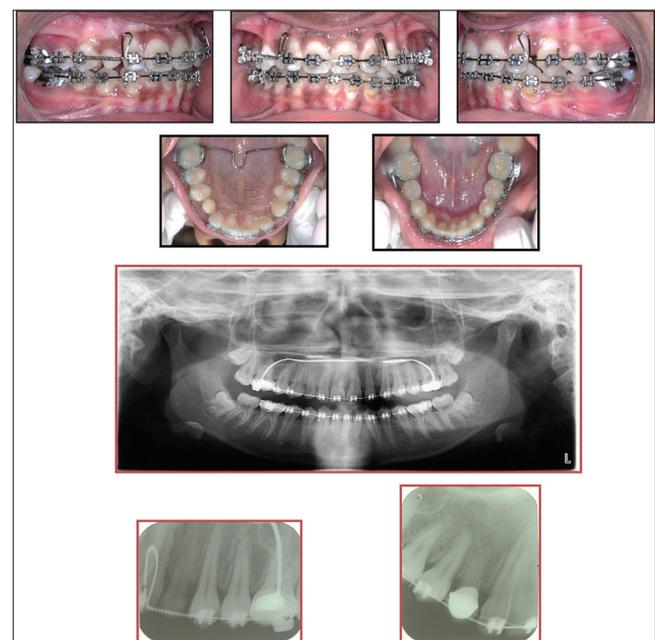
Midtreatment intraoral views and orthopantomogram for the assessment of the root position of 53 following space redistribution toward 13 reconstructions. Intraoral periapical views for the assessment of root angulations of 12 and 14 following crown placement (immediate)
